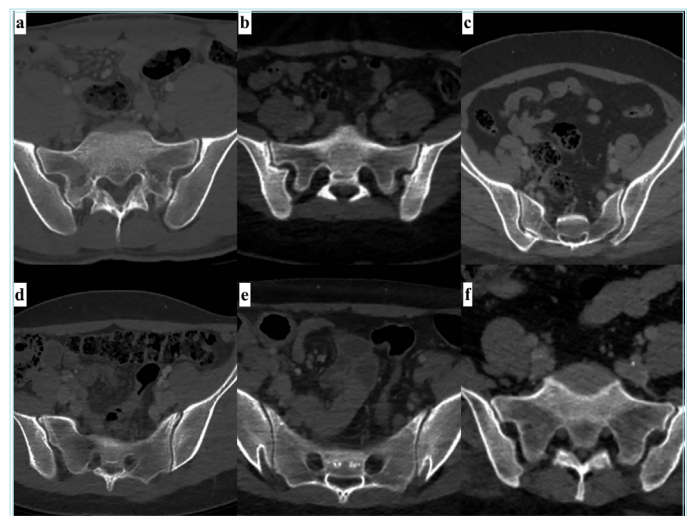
Representative computed tomography images of sacroiliac joint variants. (a) Accessory sacroiliac joint, (b) ileosacral complex, (c) crescent iliac bony plate, (d) ossification centers, (e) bipartite iliac bony plate, and (f) semicircular defect
